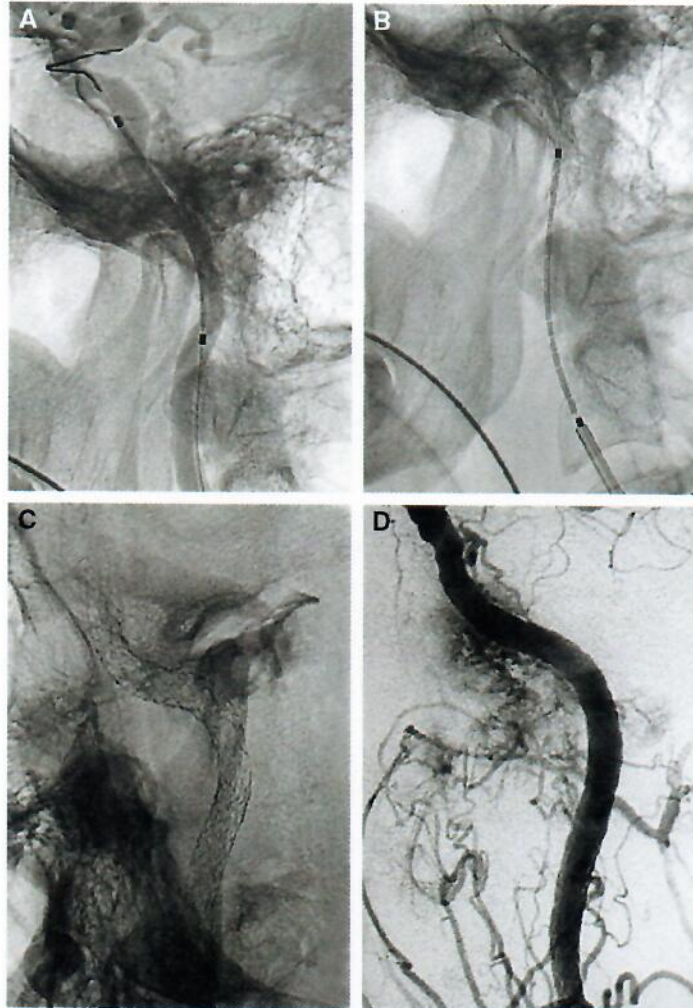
Stent insertion. (A and B) Insertion of the stents in the petrous and cervical portions of the internal carotid artery (ICA). (C) Digital x-ray in oblique projection showing the stents fully deployed into the petrous and cervical segments of the ICA. (D) Digital subtraction angiography of the ICA after stenting showing resolution of the stenosis.
